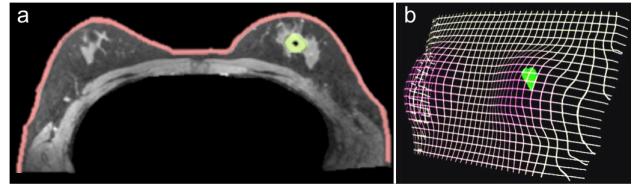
a) Example preoperative MRI acquired in the supine position, with the tumor indicated in green. Injected gadolinium-based contrast agent causes the tumor to appear bright on MR images, so that its location and extent can be identified. b) Example skin and tumor meshes uploaded to the HoloLens as holograms. These two structures can be segmented out from the MR images semi-automatically.
